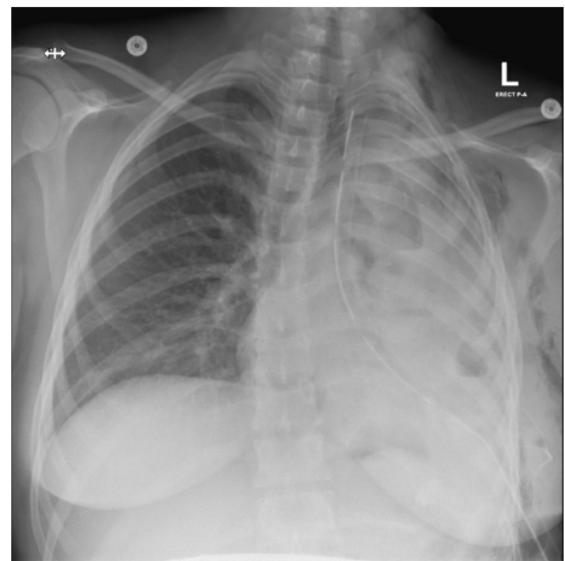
A chest X-ray revealed nearly complete whiteness of the left hemithorax with volume loss since the previous radiograph and a few small air-fluid levels. Stable left apical chest drain and surgical emphysema in the left chest wall
